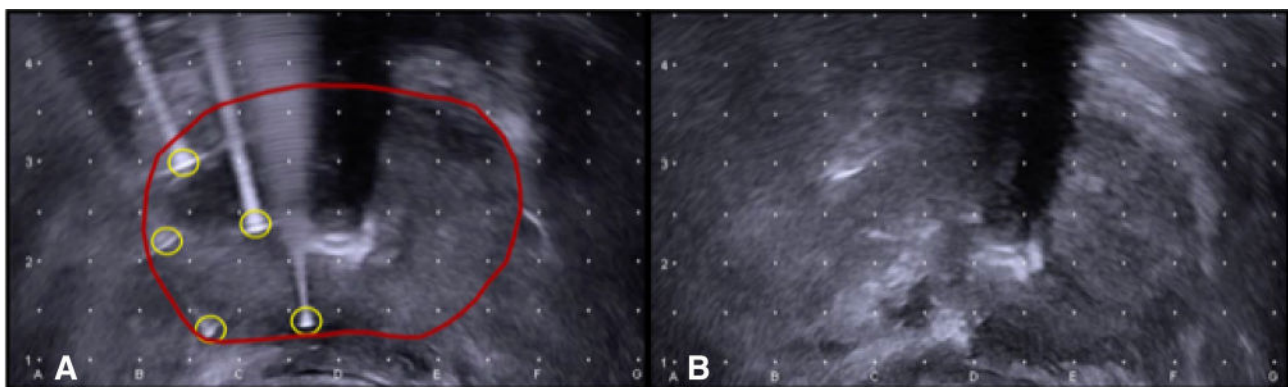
a Axial ultrasound image showing placement of five IRE electrodes (yellow circles) positioned in the posterior right apex of the prostate (red); b Ultrasound image showing post treatment destruction in the expected area. ©The Authors
